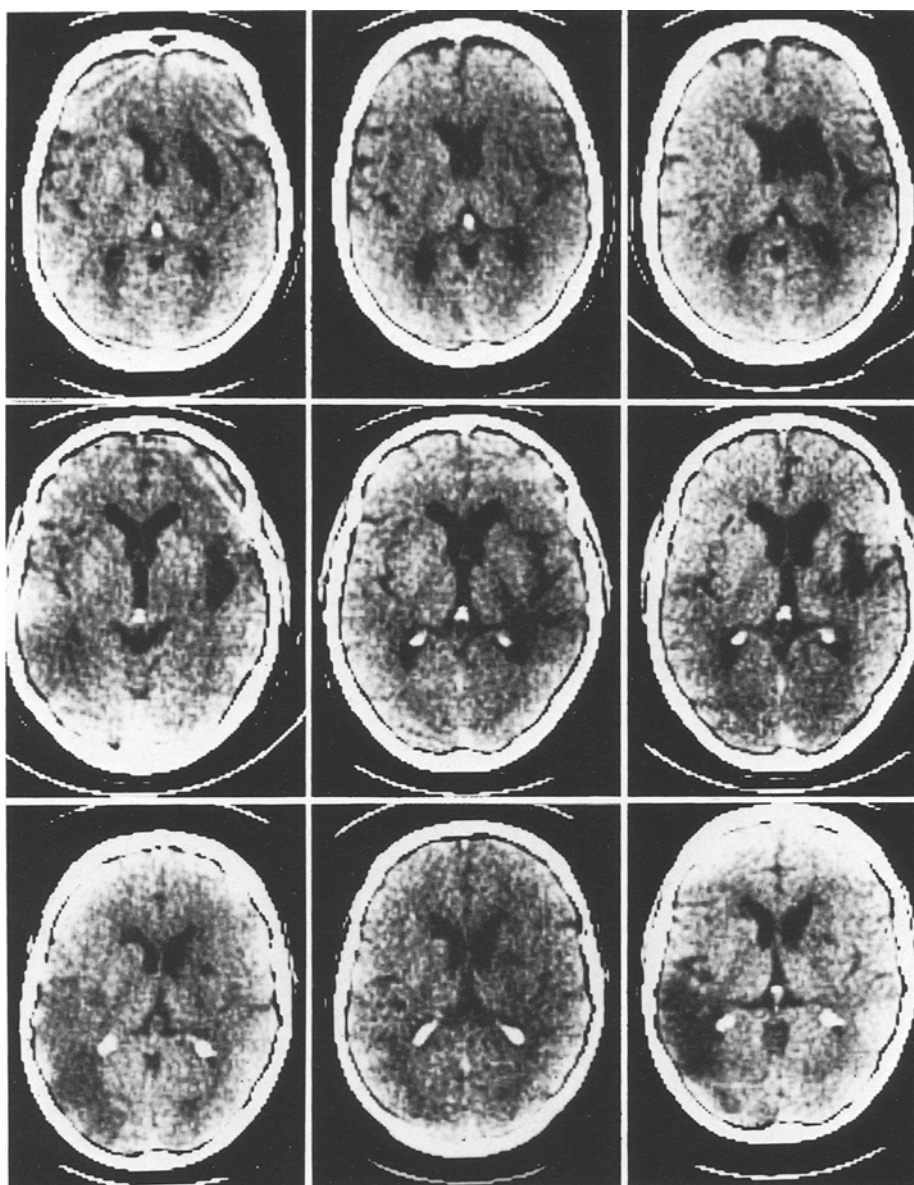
Three cases showing the fogging effect on CT scans performed during the first week, between the second and third weeks, and 6 months after stroke. The hypodense area, which had almost disappeared on the second scan, returned to hypodensity on the third scan
